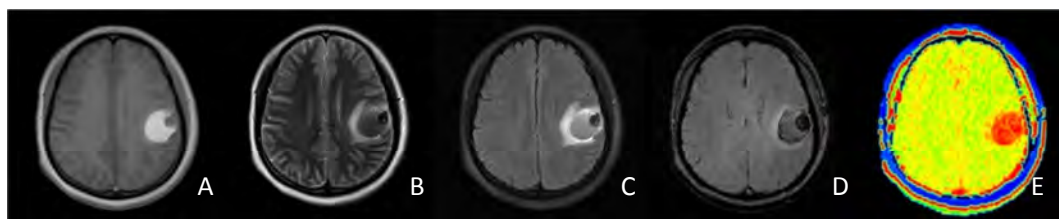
A 24-year-old female with cerebral hemorrhage in the left temporal lobe. The center of lesion shows hyper- and iso-intensity on T1w image (A), iso- and hypo-intensity on T2w image (B), iso- and hypo-intensity on FLAIR (C) and heterogeneous signal intensity on susceptibility-weighted image (D). The APT color map (E) demonstrates the lesion is hyperintense.
